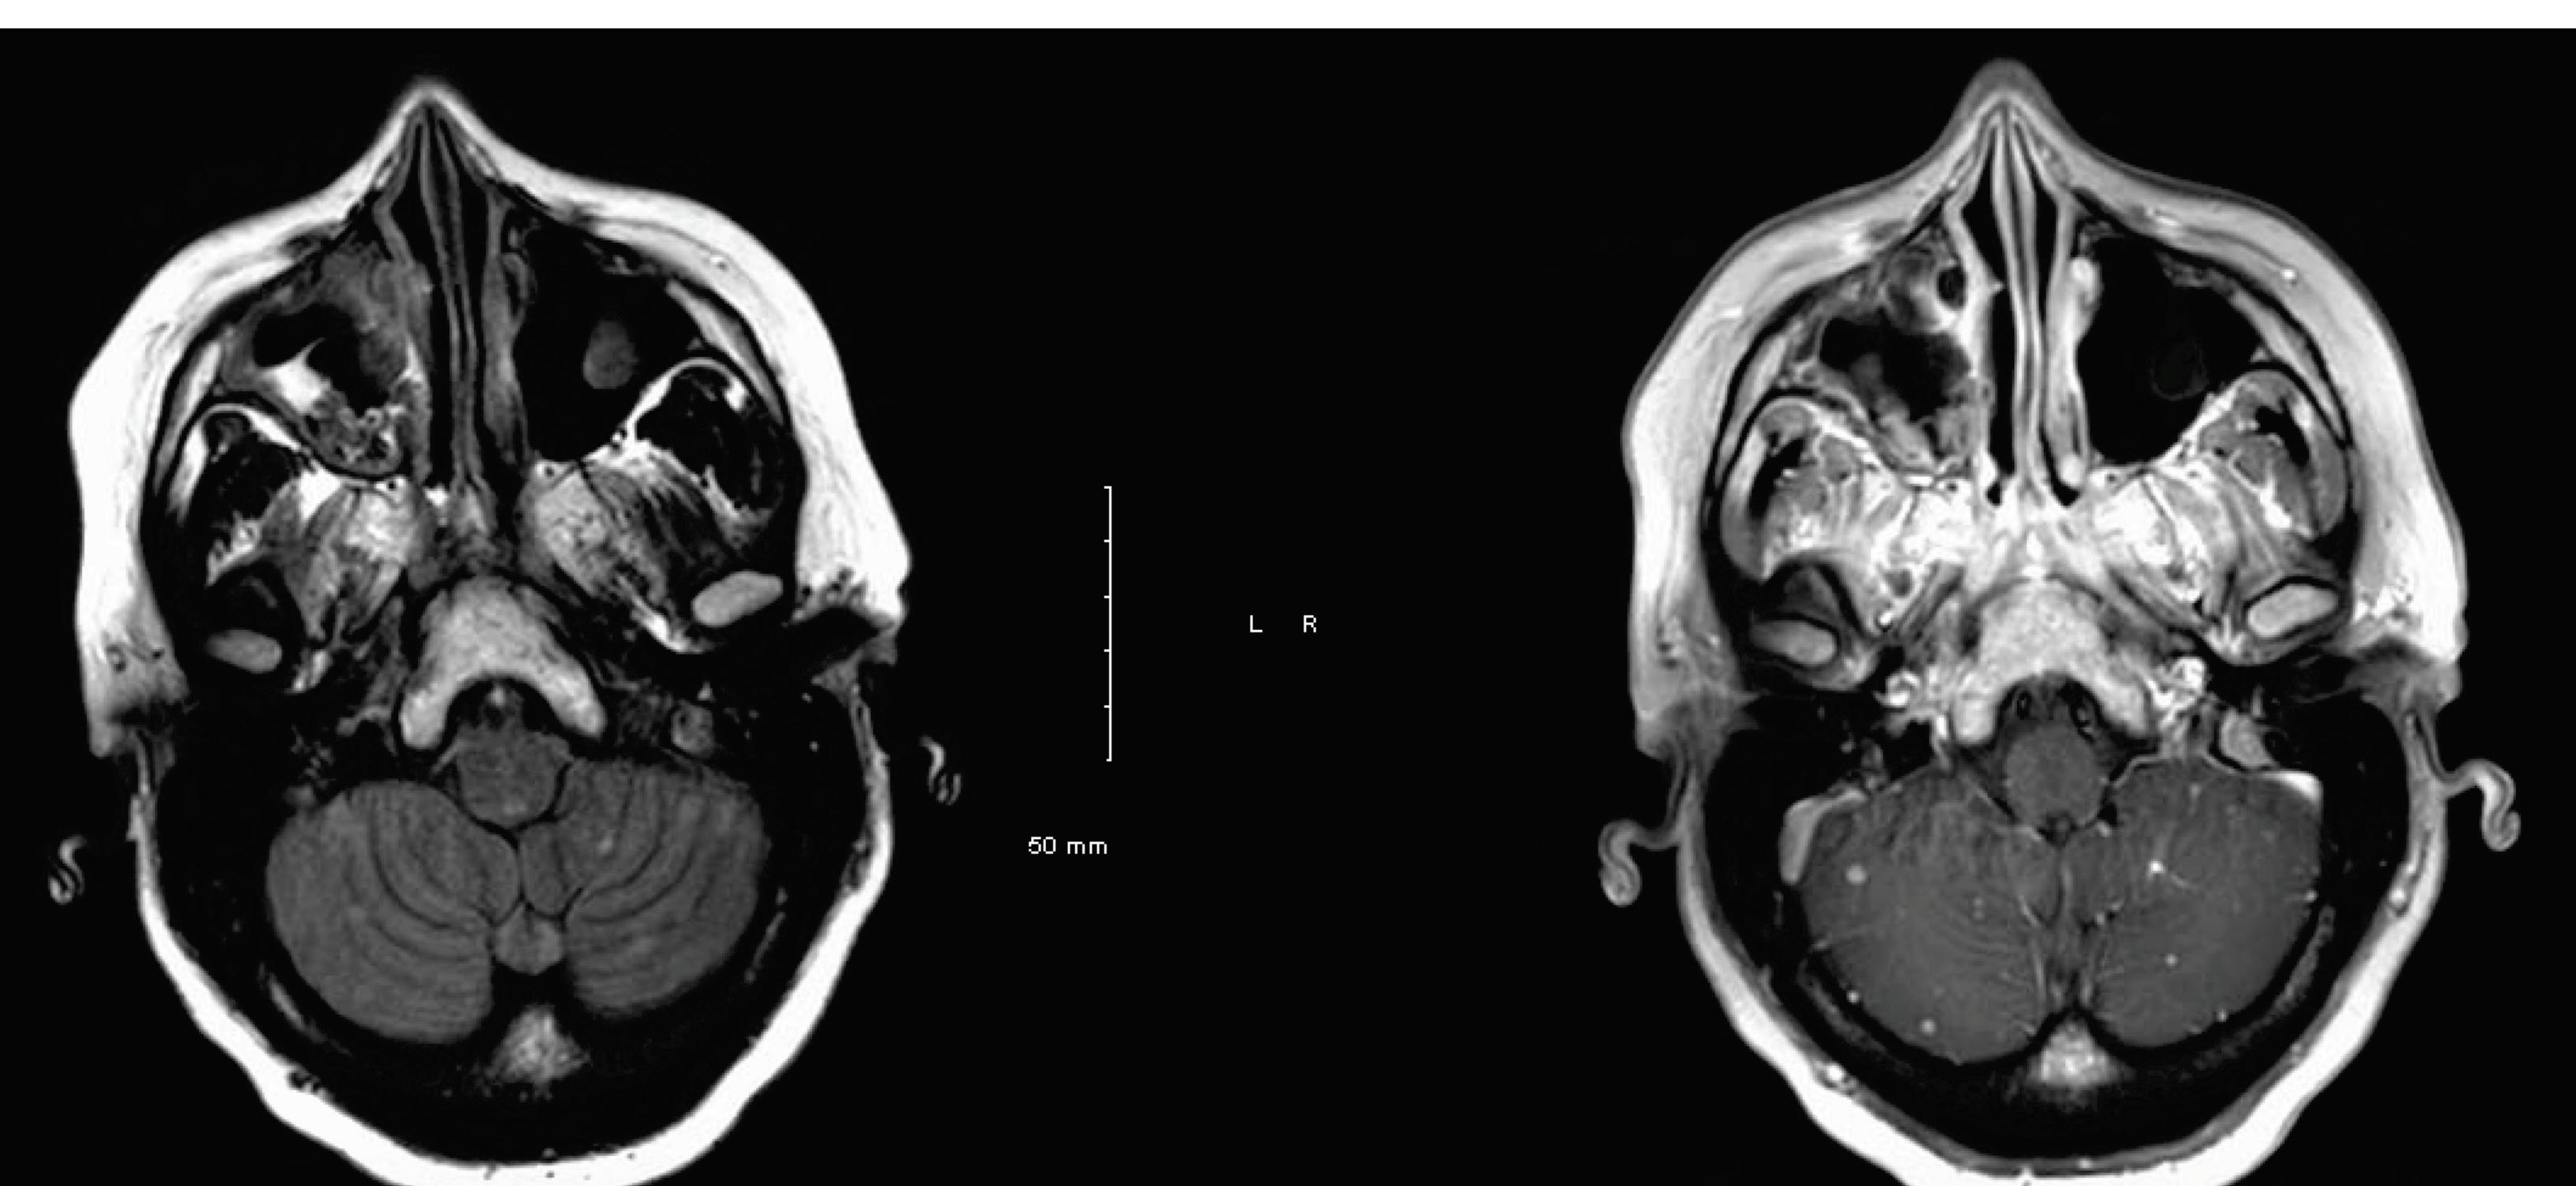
Gadolinium-enhanced MRI brain with bilateral cerebellar enhancing punctate lesions without diffusion restriction or gradient echo signal
